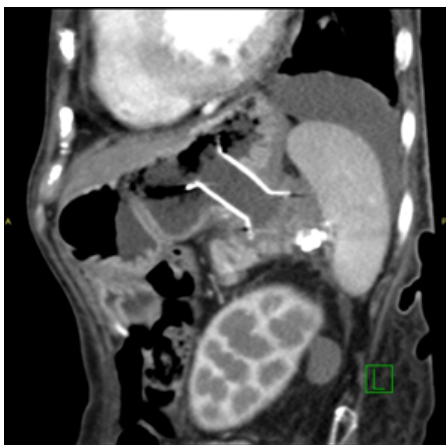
CT abdomen after 6 months of stent insertion showing stent in-situ and resolution of lesion.
